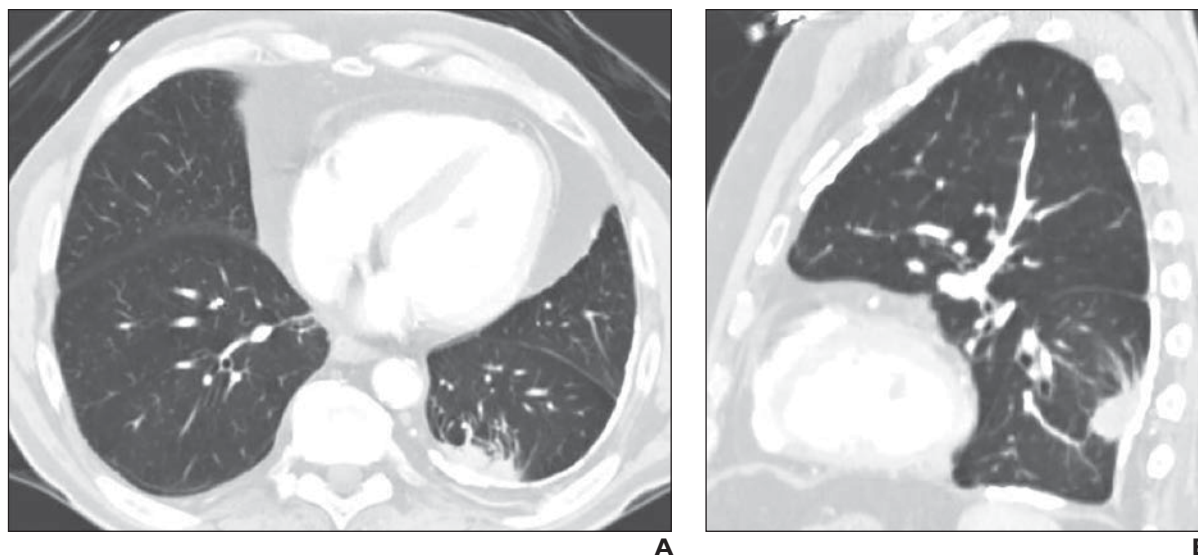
Availability bias. A and B, Axial (A) and sagittal (B) CT images of 50-year-old man with history of nodule seen at left base on chest radiography (not shown). CT study was interpreted as showing left lower lobe subpleural nodule “concerning for neoplasm.” However, this nodule shows classic characteristics of round atelectasis. Radiologist reported missing lung cancer day before this interpretation, predisposing her to diagnose lung cancer.
